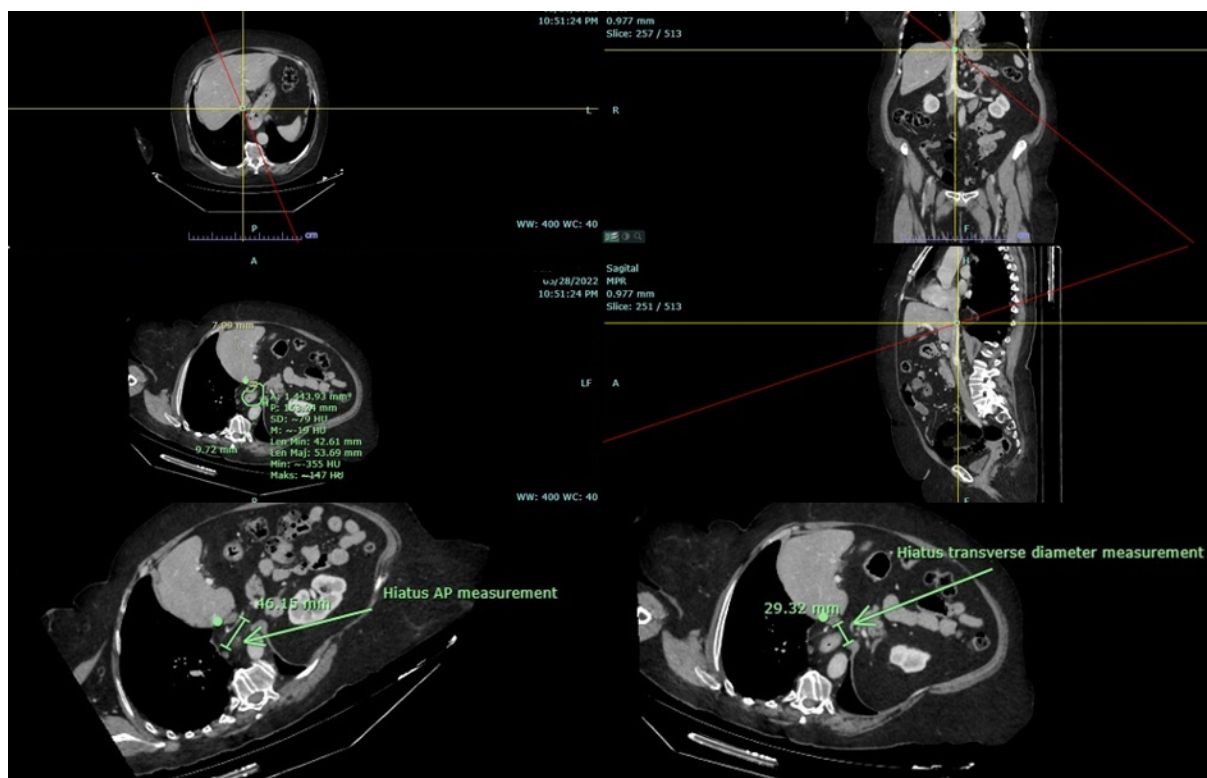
Measurement of the hiatal surface area on axial, coronal, oblique axial, and sagittal computed tomography images with the corrected angle (Measurements of hiatus antero-posterior and transverse diameter using reformatted oblique axial images are shown).
